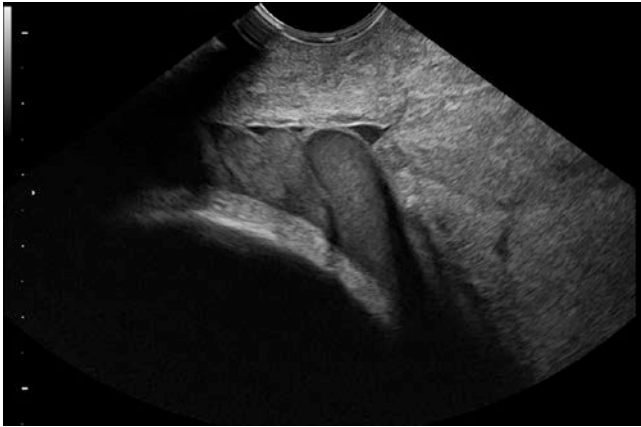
Vasa previa at transvaginal ultrasound
